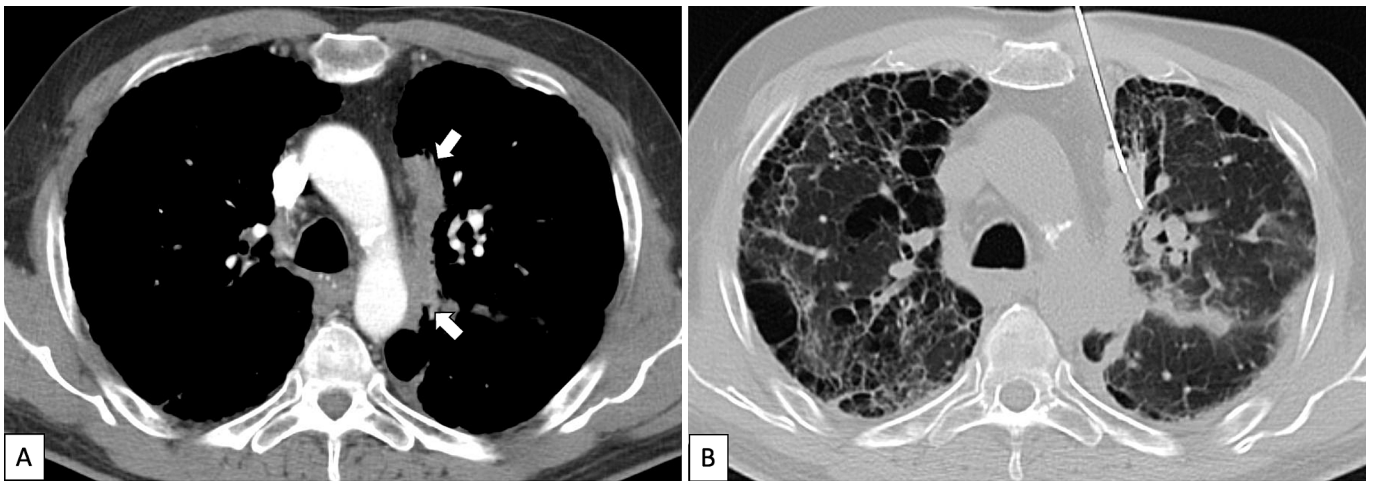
A. Contrast-enhanced CT of a left paramediastinal solid tissue (arrows) referred for transthoracic needle biopsy. B. The CT-guided biopsy procedure was planned to minimize needle traversal of confluent emphysema by crossing the anterior mediastinum. The final diagnosis was lung adenocarcinoma.
